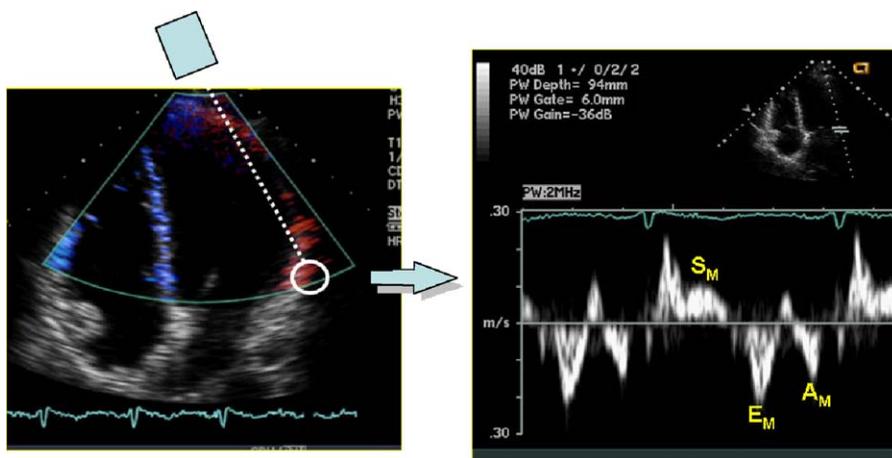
Tissue Doppler velocities. Color-encoded tissue Doppler velocities obtained in the apical four-chamber view are shown on the left panel. Spectral pulsed Doppler systolic ( $S_M$ ), early diastolic ( $E_M$ ), and atrial contraction ( $A_M$ ) myocardial velocities obtained at the base of the lateral wall are shown on the right image.
